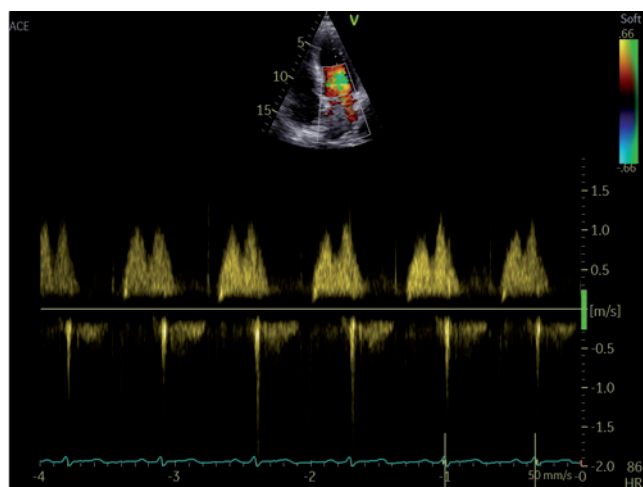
Trans-mitral continuous-wave-Doppler showing the diastolic dysfunction.
